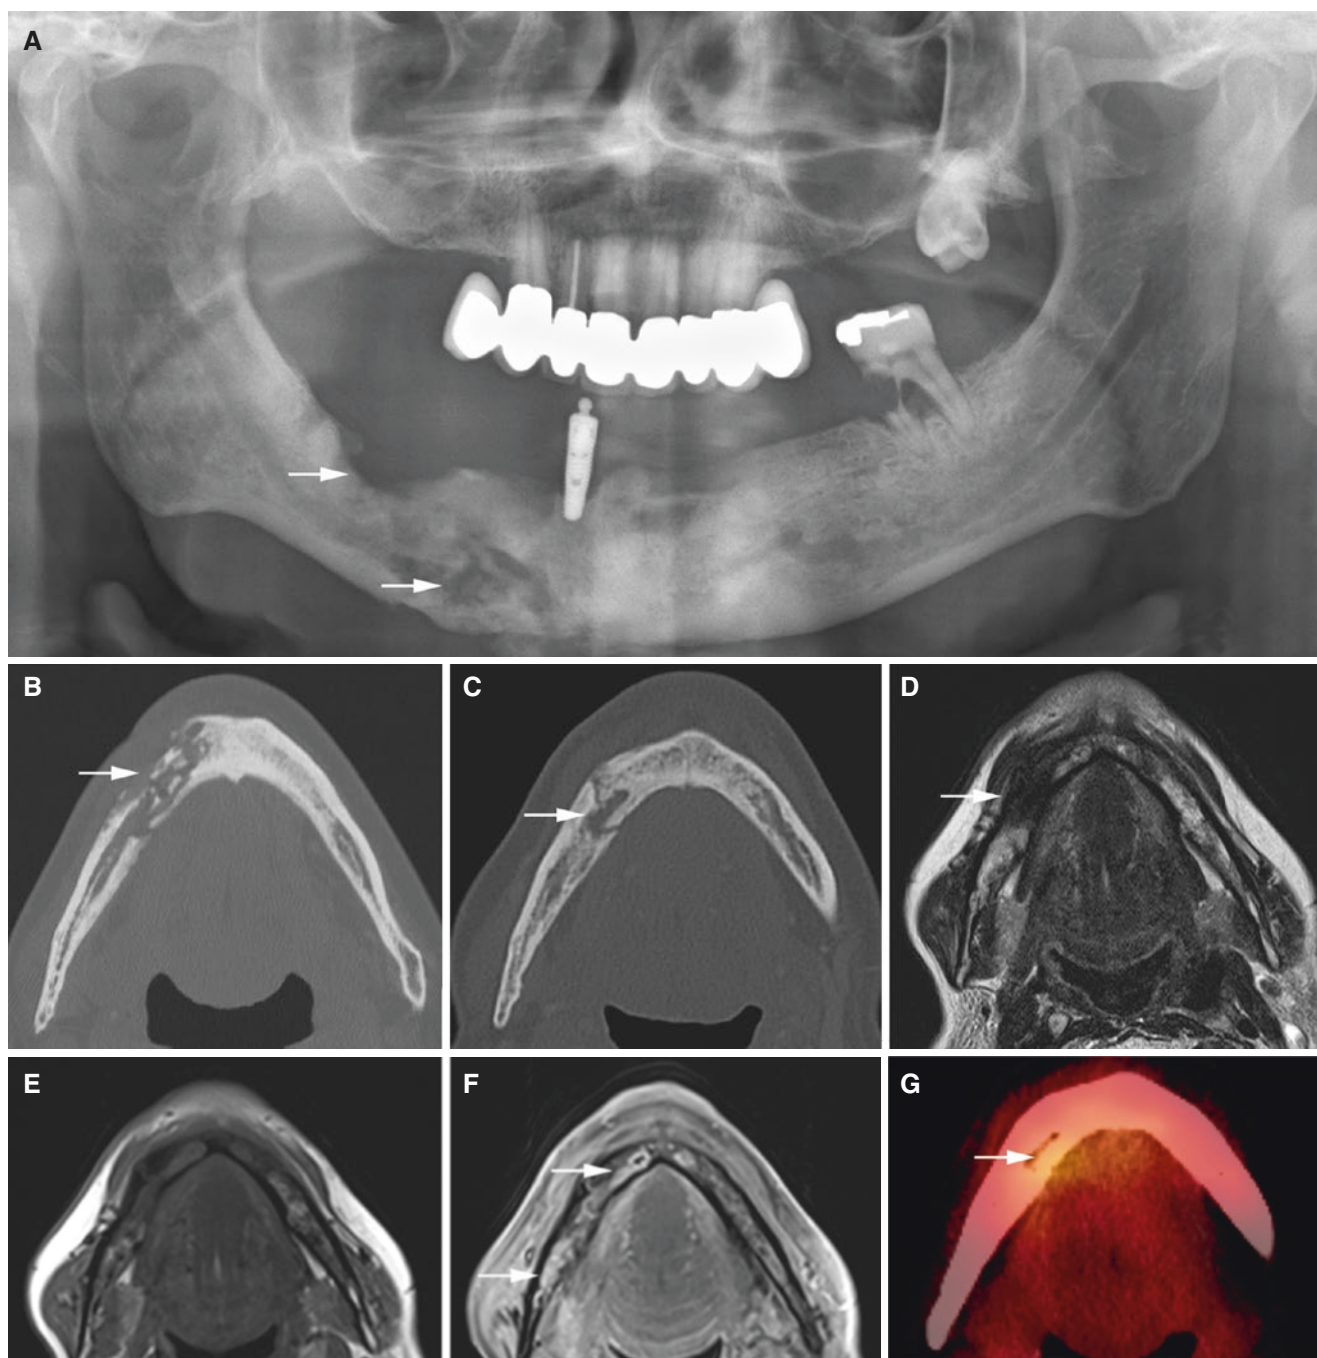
Osteoradionecrosis, mandible; 47-year-old male with right-sided surgically treated sublingual cancer and postoperative radiation therapy. (A) Panoramic view shows bone destruction (arrows). (B) Axial CT image shows destruction with sequestration in right mandible (arrow). Nine months later, (C) axial CT image shows bone healing, but still fissure-like bone defect (arrow). (D) Axial T2-weighted MRI
